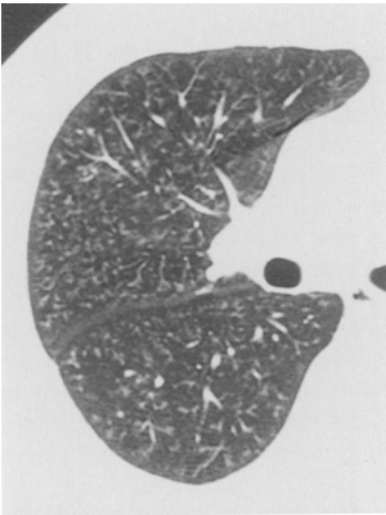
HRCT scan of p type opacities. Numerous tiny branching lines of ill-defined punctate opacities, usually in a centrilobular location, are seen
